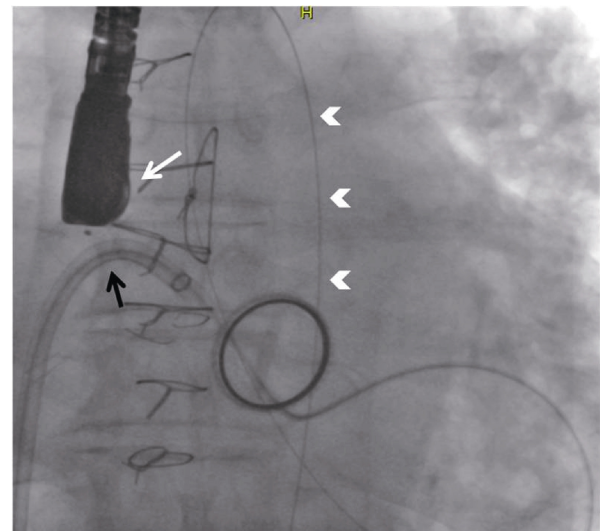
Fluoroscopic view of transseptal steerable sheath (black arrow) and guide wire which advanced to descending aorta (white arrowheads). White arrow designates the transesophageal echocardiography probe.
